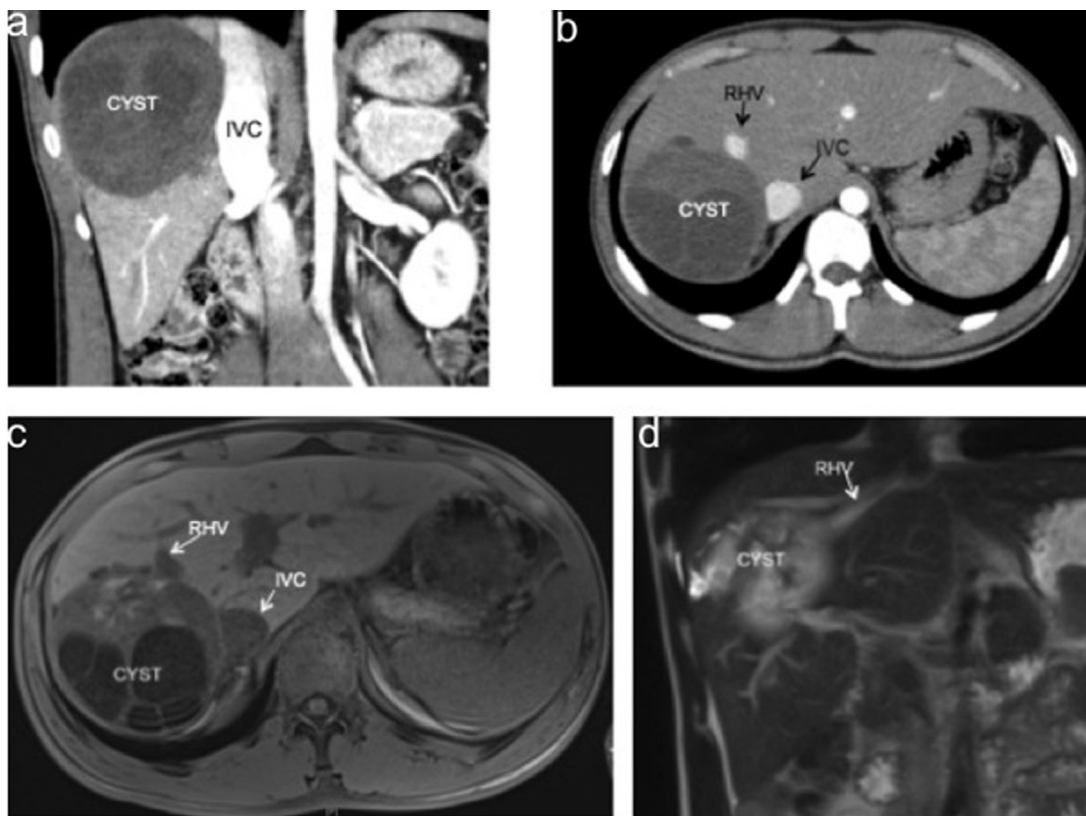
(a–b) CT-scan before surgery, (c–d) MRI confirms the vascular rapport of the cyst and its communication between with the biliary tree (d). CYST: hydatid cyst, IVC: inferior vena cava; RHV: right hepatic vein.
